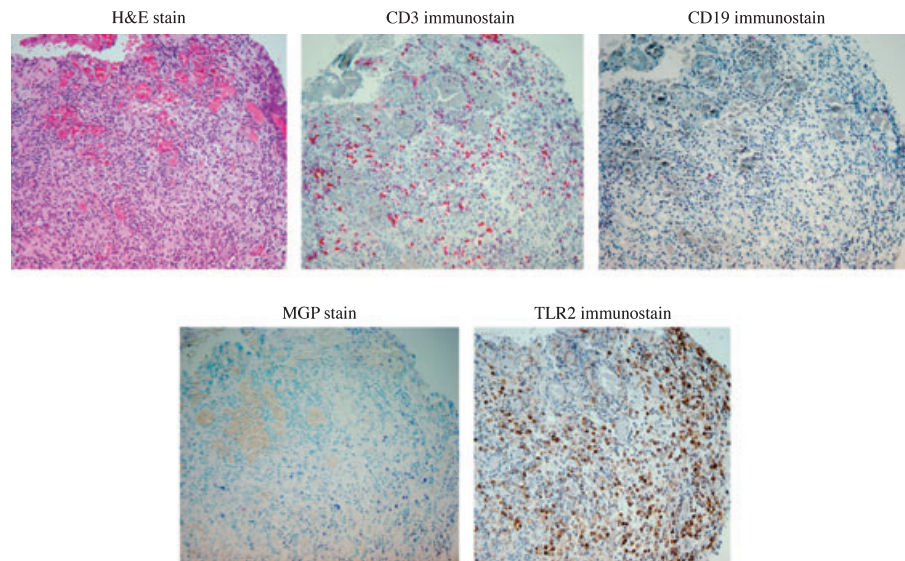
Representative serial sections of a symptomatic periapical granuloma showing higher numbers of CD3⁺ T cells than CD19⁺ B cells associated with the expression of TLR2. Also note that a number of TLR⁺ positive sites do not have CD3⁺ T cells, CD19⁺ B cells or MGP⁺ cells associated with them (×100).
